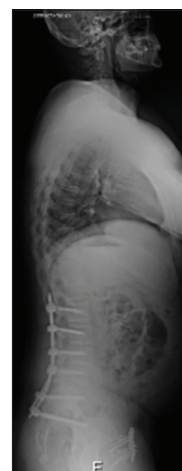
Lateral full spine standing radiograph (1 year follow-up)
